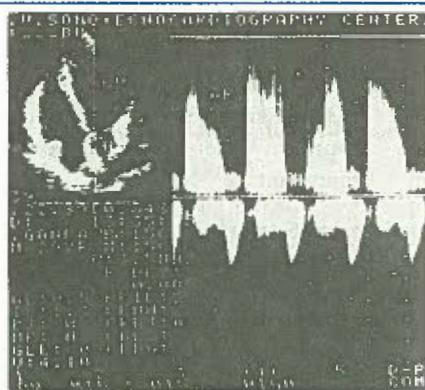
2D Echo with Doppler showing aortic regurgitation
